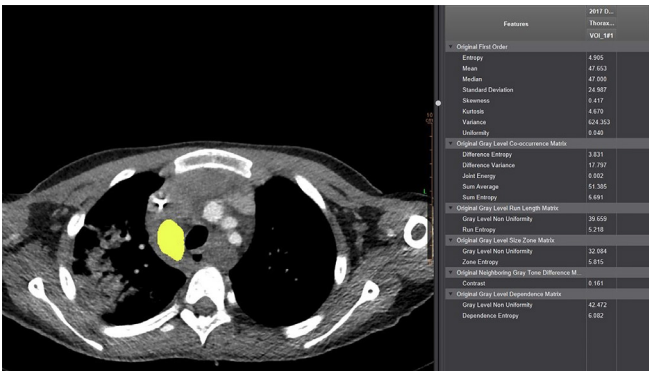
Axial CT image; 1 in Figure 1. In the tissue analysis program after cure chemotherapy, the results of tissue analysis of the ROI area (yellow area) and statistical parameters drawn for lymphadenopathies with shrinkage in the mediastinum are monitored
